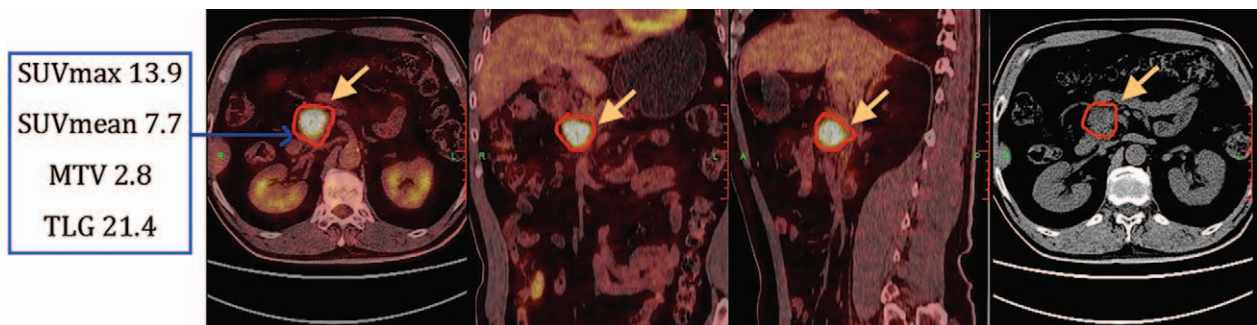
Male, 65 years old, pancreatic head cancer. ¹⁸F-FDG PET/CT image showed a lesion located in pancreatic head with increased radioactivity uptake. SUVmax and SUVmean above the cut-off value, MTV and TLG were below the cut-off value, and the LDT was 3.2 cm. The patient was firstly treated with SBRT therapy, followed by the S-1 based chemotherapy. OS of this patient was 33 months, and PFS was 28.5 months. MTV=metabolic tumor volume, OS=overall survival, PFS=progression-free survival, SBRT=stereotactic body radiation therapy, TLG=total lesion glycolysis.
